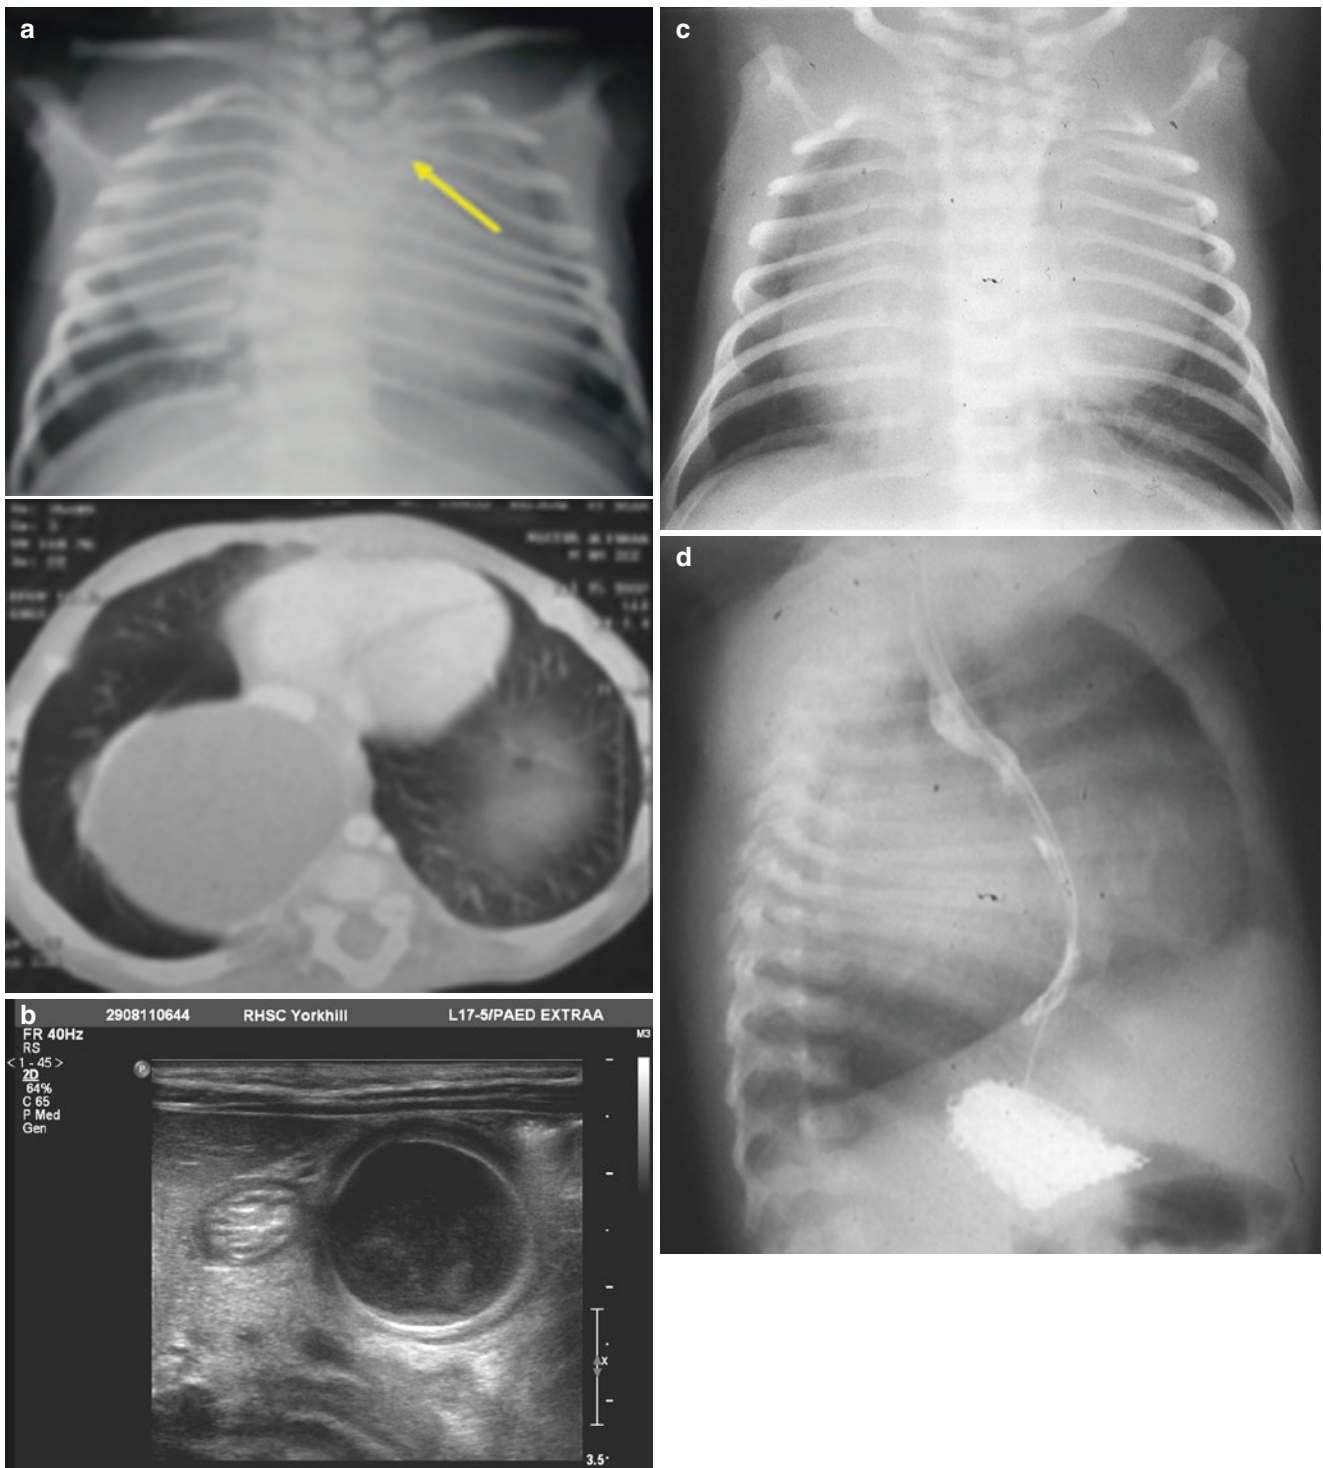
(a) Foregut duplication cyst. (b) Foregut duplication cyst scan of the chest. (c) Foregut duplication cyst with cervical vertebral abnormalities. (d) Lateral chest X-ray Foregut duplication cyst with dye in the oesophagus showing it displaced
